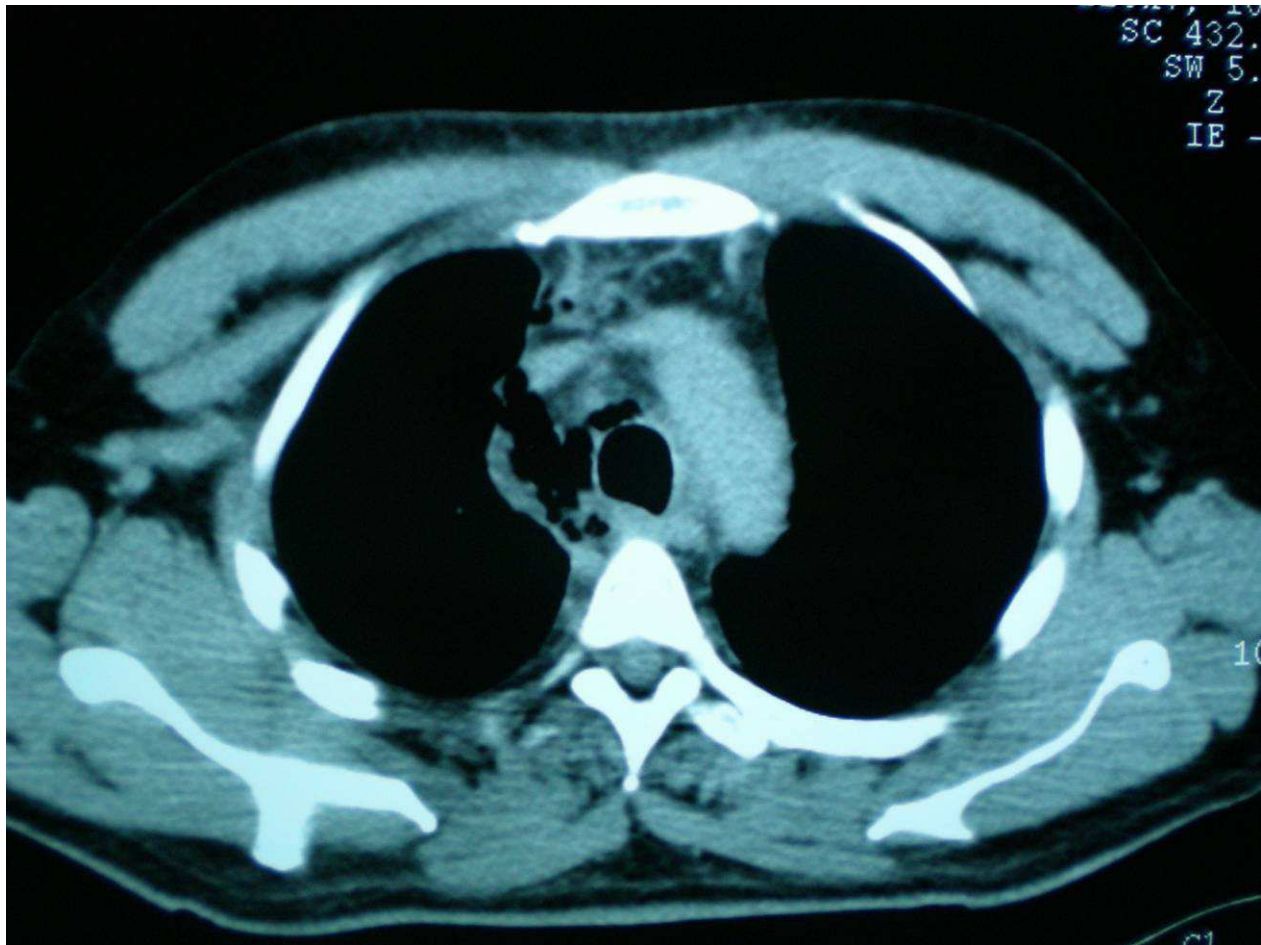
chest CT axial sections showing a mediastinal retro cellulite and laterotrachèale right.
